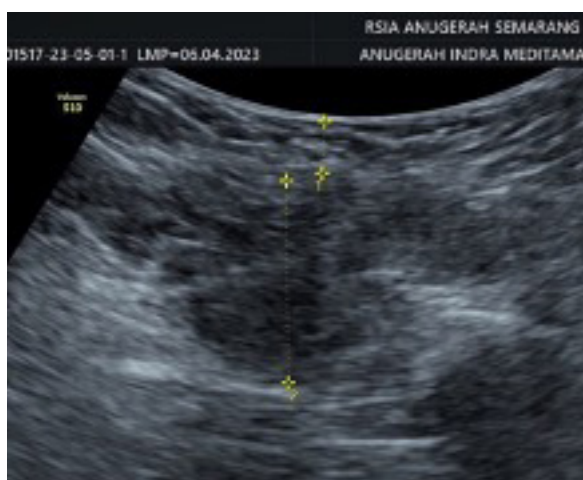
Ultrasound finding an iso-signal intensity with areas of partial high signal intensity with uneven edges and tight adhesion to the surrounding tissue.
